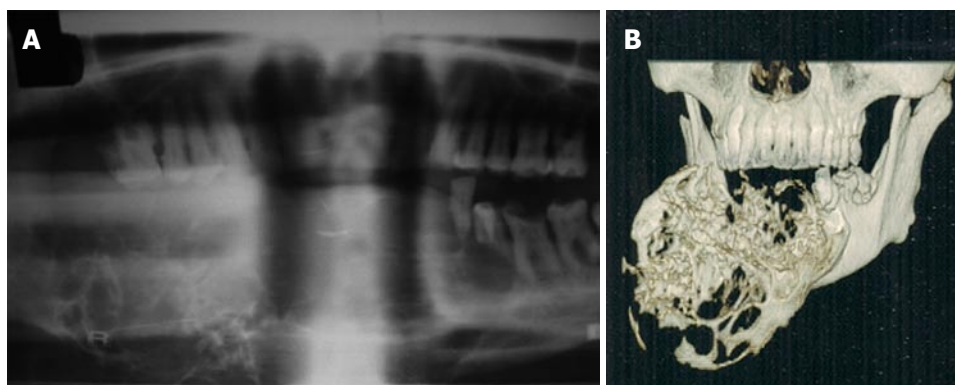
Orthopantomograph (A) and 3D computed tomography (B) showing honeycomb lesion.
